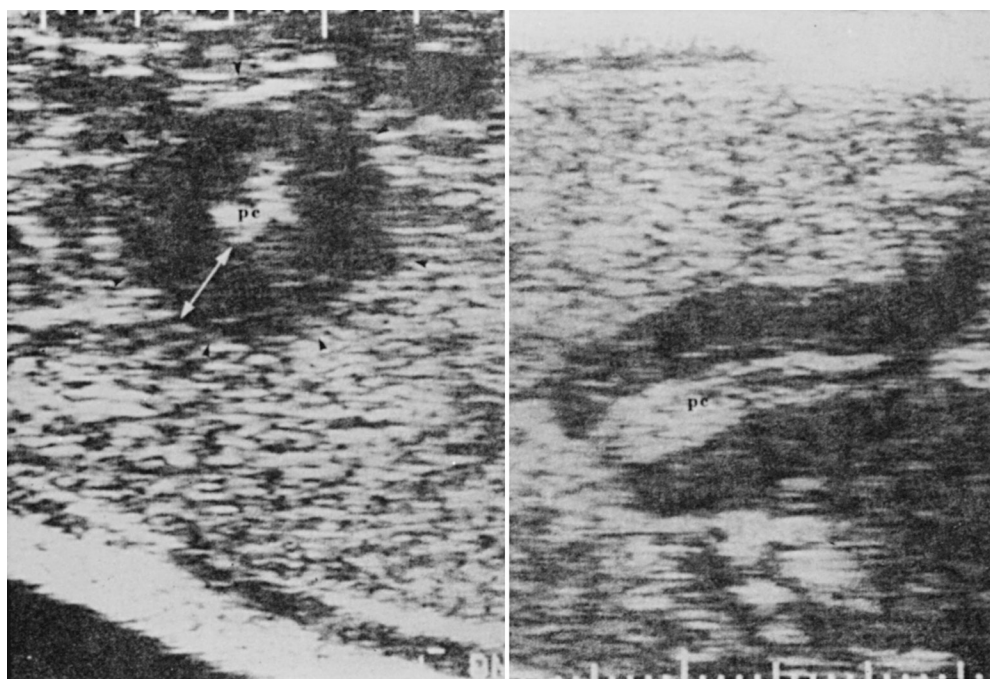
Pyloric stenosis. Cross-sectional (*left*) and transverse (*right*) sonograms of hypertrophic pyloric stenosis, showing increased thickness and length of pyloric muscle. pc, pyloric channel.
